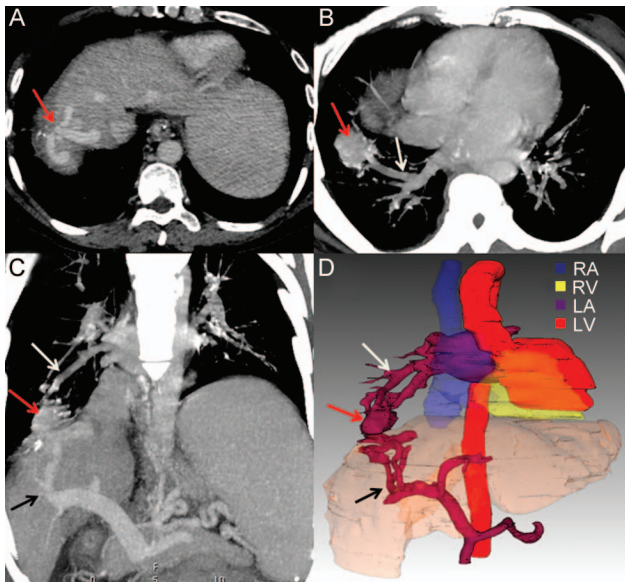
Axial (A and B), oblique coronal (C), and 3-dimensional maximum intensity projection (MIP) with volume-rendered (D) contrast-enhanced computed tomography images of the chest and upper abdomen revealed a cluster of collaterals (red arrows) from the anterior and posterior branches of the right portal vein (black arrows in C and D) involving the posterior segment of the right lobe of the liver and extending through the diaphragm up to the anterior-basal segment of the right lower lobe and ultimately draining into the left atrium via the right inferior pulmonary vein (white arrows in B–D). See D for cardiac chamber key.
